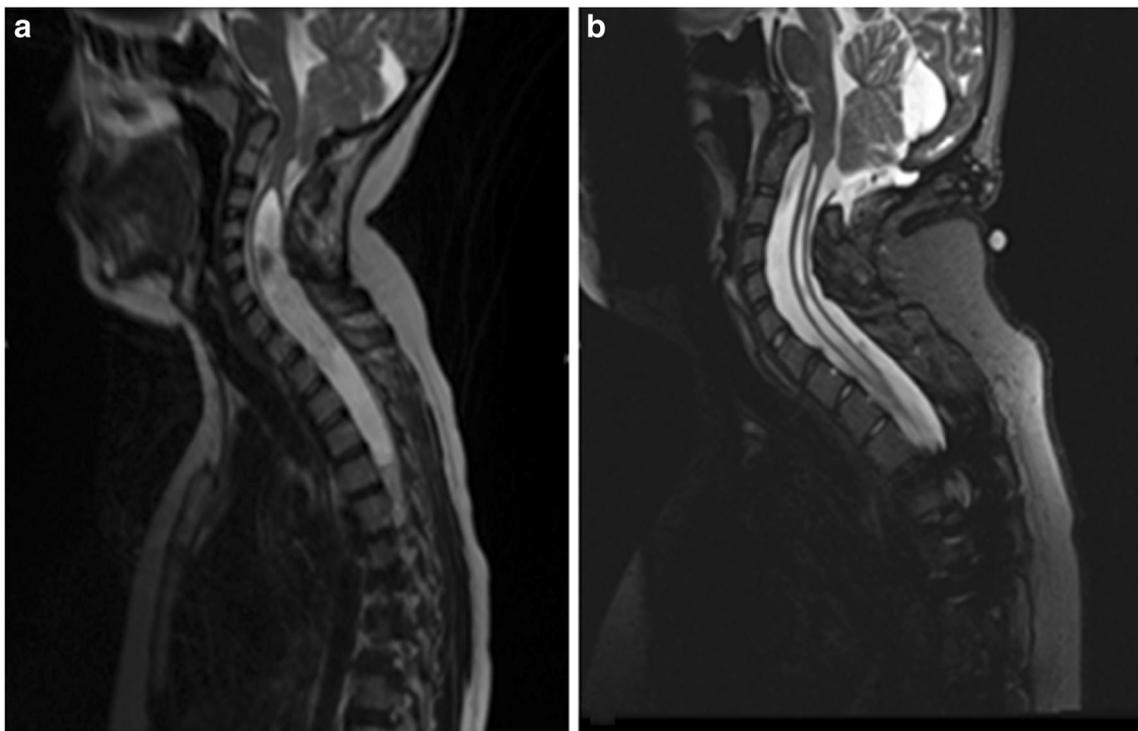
a Preoperative sagittal T2-weighted magnetic resonance image demonstrating the patient's Chiari I malformation with the cerebellar tonsils lying at the C2 level and a concomitant syrinx extending from C2–C3 to T5. b Sagittal T2-weighted magnetic resonance image performed 7 years postoperatively showing the pseudomeningocele that
